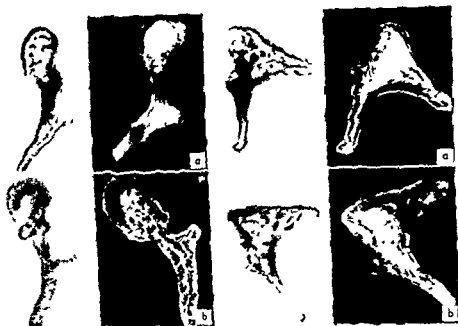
Malleus and incus: (a) new born infant (b) child. Spongiosa of the lacunar type. Identity of elements shown by radiographic and osteo-micropneumographic pictures.
